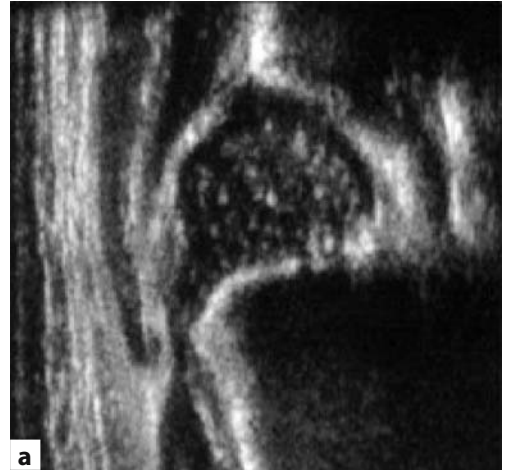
a Two weeks, right hip. This sonogram is not usable, because the lower limb is missing, but the hip is centred. b 1, Zona annularis; 2, zona centralis; 3, the lower limb is missing
